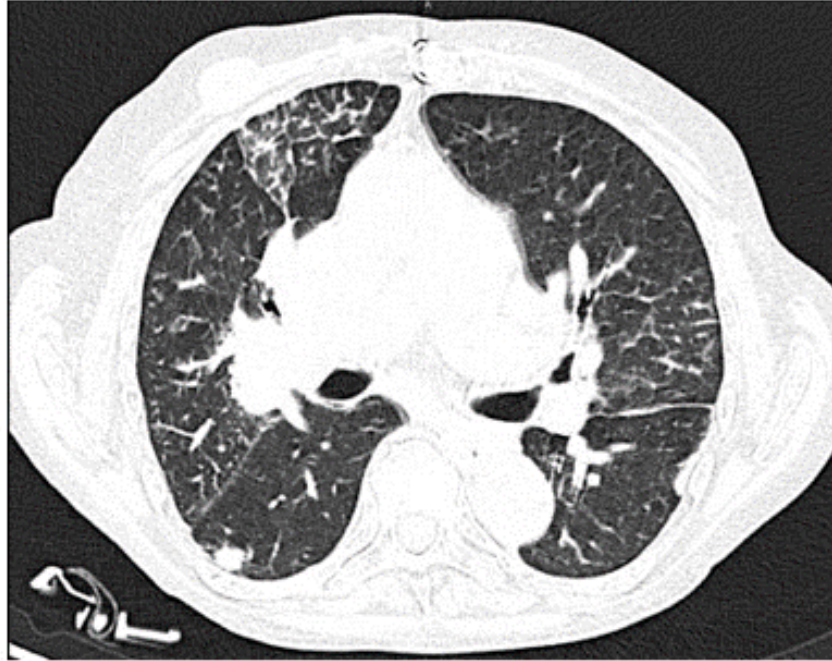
Computer Tomography (CT) Chest Segment
